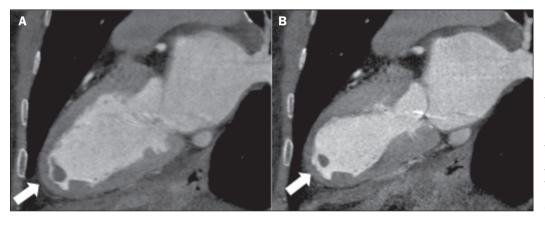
Coronary computed tomography angiography of a 78-year-old patient, reconstructed in a two-chamber view, in diastole (A) and systole (B), showing contractile alterations typical of takotsubo cardiomyopathy, leading to apical ballooning. Note the intracavitary thrombus in the apical region of the LV (arrows), a complication described in this pathology.
